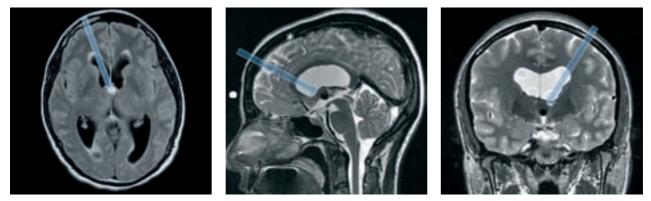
These MR images in an axial, sagittal and coronal plane have a superimposed trajectory intended for endoscopic removal of a colloid cyst of the third ventricle. The diameter of the endoscopic sheath has been taken into account to more accurately reflect structures at risk. The coronal suture is depicted with an asterisk.
